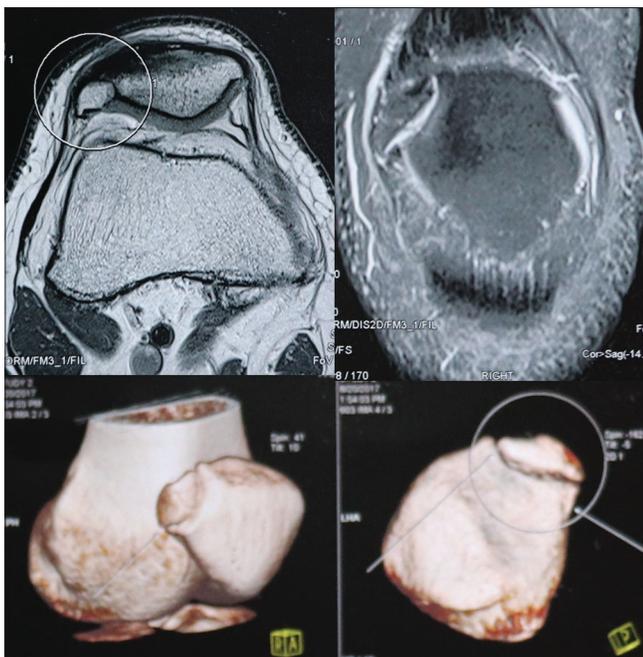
Magnetic resonance imaging and computed tomography scan showing the superolateral bipartite fragment
